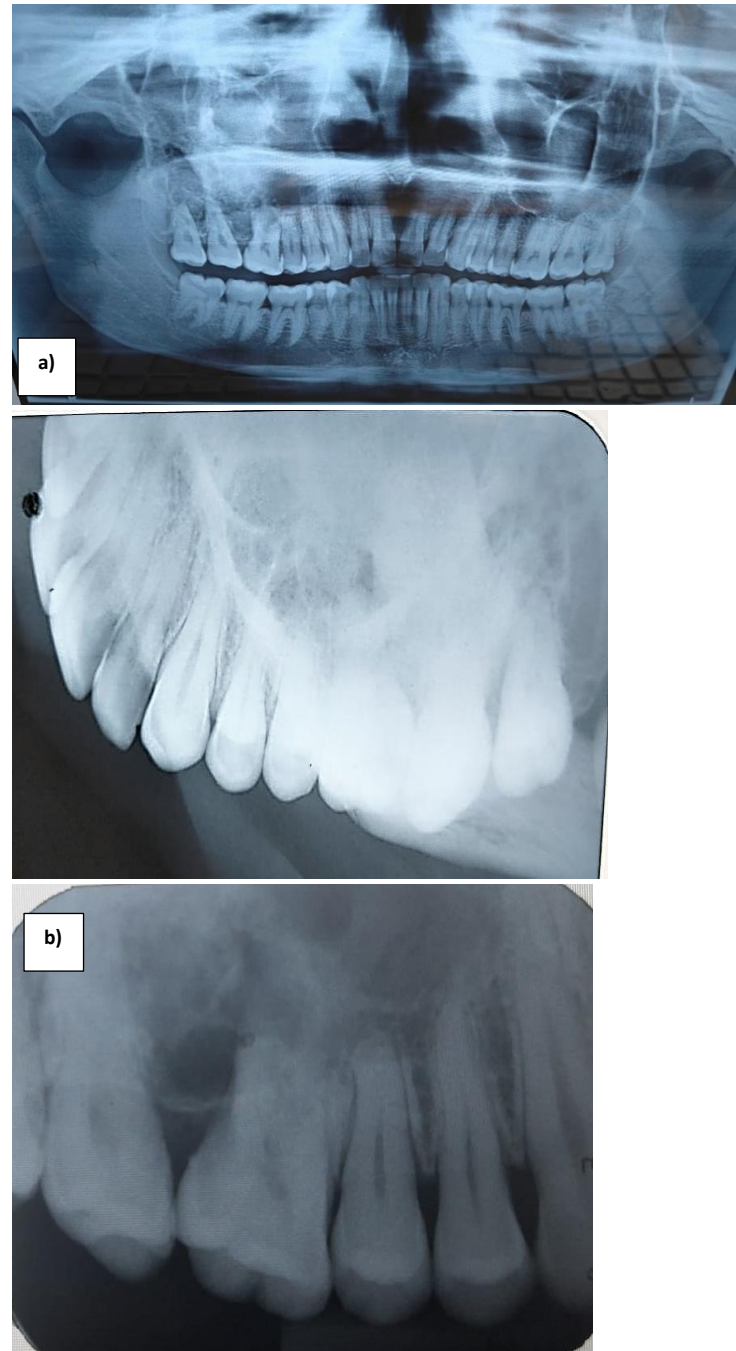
a) Orthopantomogram (OPG), b) Intraoral occlusal radiograph reveals multilocular radiolucency with ill-defined margins involving apices of molar teeth c) Intra oral periapical radiograph (IOPA) reveals multilocular radiolucency involving apices of molars and root resorption of first molar
